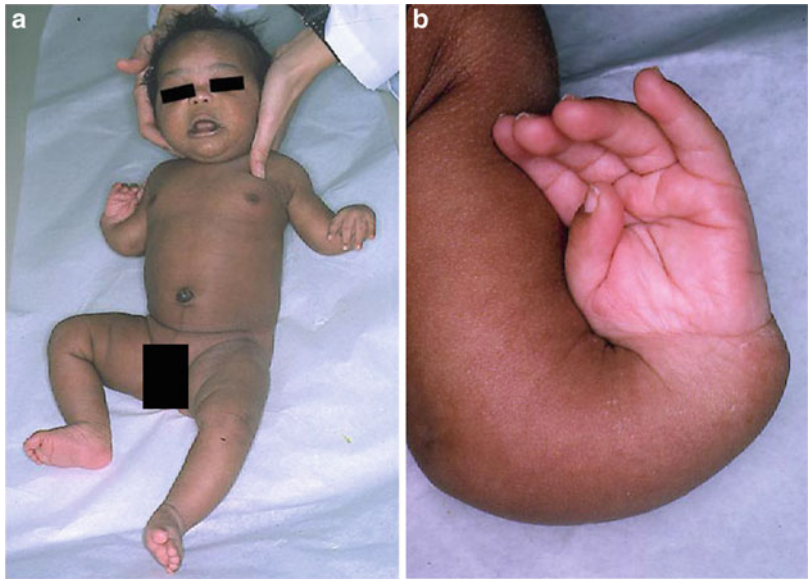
(a–c) A child with Holt-Oram syndrome showing bilateral club hands, absent radius, and absent thumbs, demonstrated by radiographs
